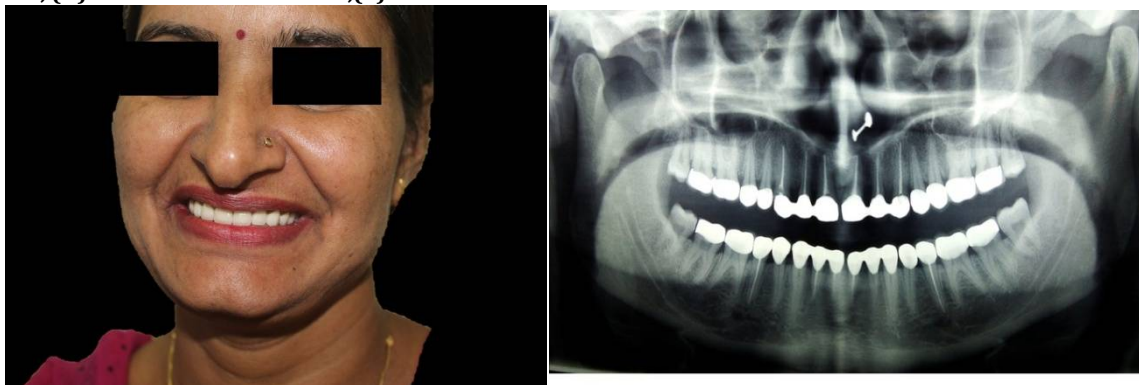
Post-Operative Figure 13:- Post-Operative Radiographic view
